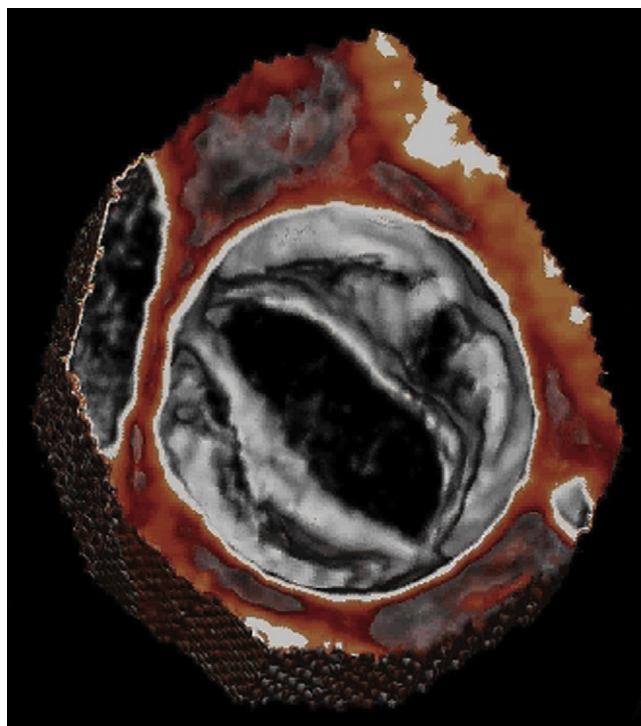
Accurate imaging is critical for successful minimally invasive and catheter-borne operations, particularly if they involve the beating heart. This 4-dimensional computed tomographic image allows very accurate localization of the calcium on a bicuspid aortic valve.
